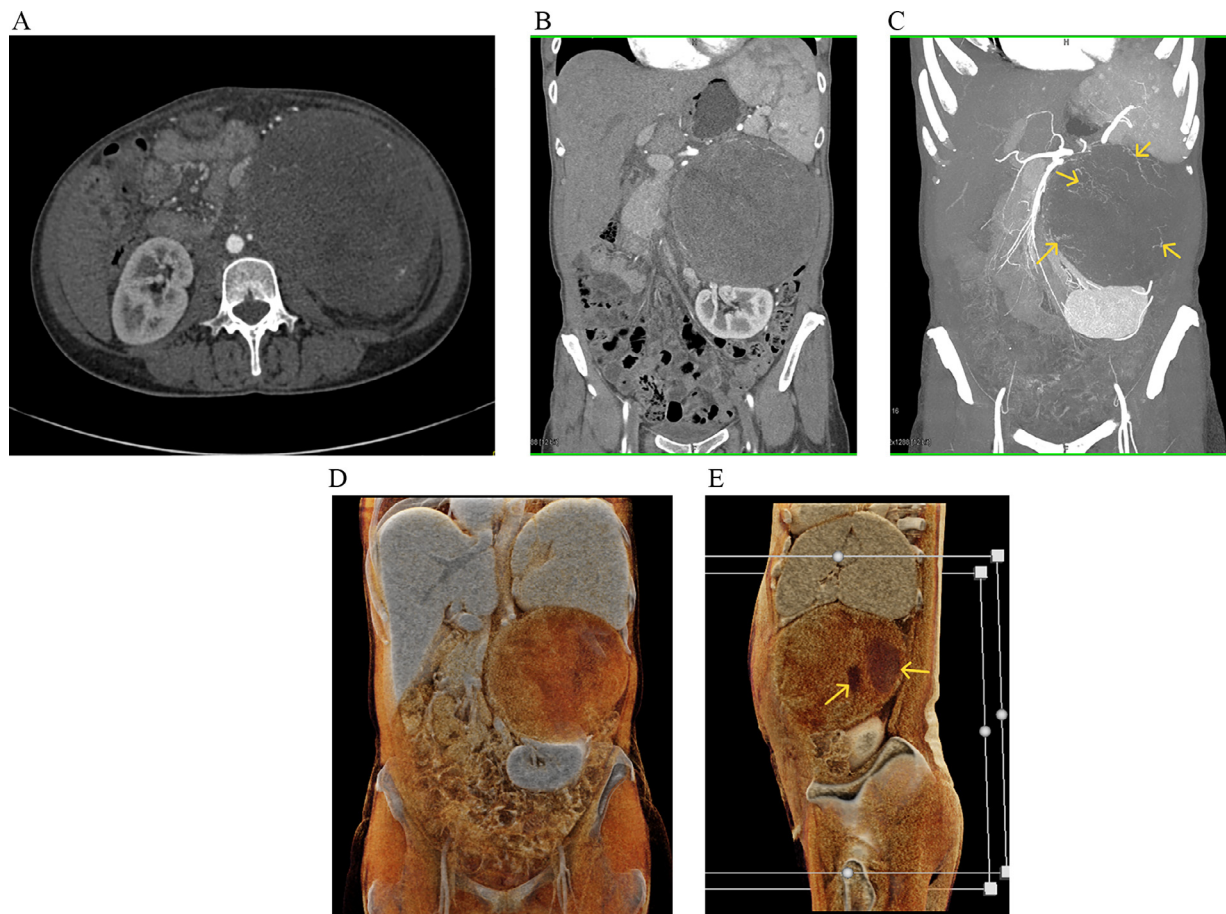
CT scan demonstrates 17 cm solid mass with areas of necrosis on axial and coronal views (A,B). Maximum intensity projection imaging (C) shows areas of neovascularity (arrows) and compression of the left kidney. Finally, the cinematic rendered images (D,E) show the tumor necrosis (arrows) with displacement of the left kidney downward. Sharp margins of the tumor are nicely defined.
